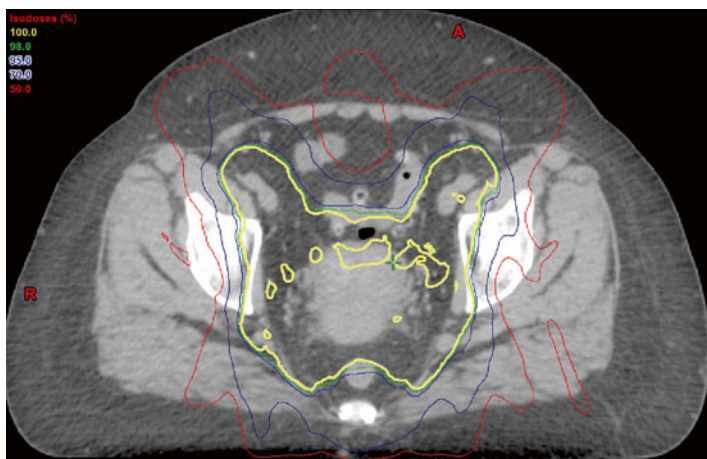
Axial CT view of an image-guided IMRT plan for cervical cancer. Image courtesy of C. Yashar.
